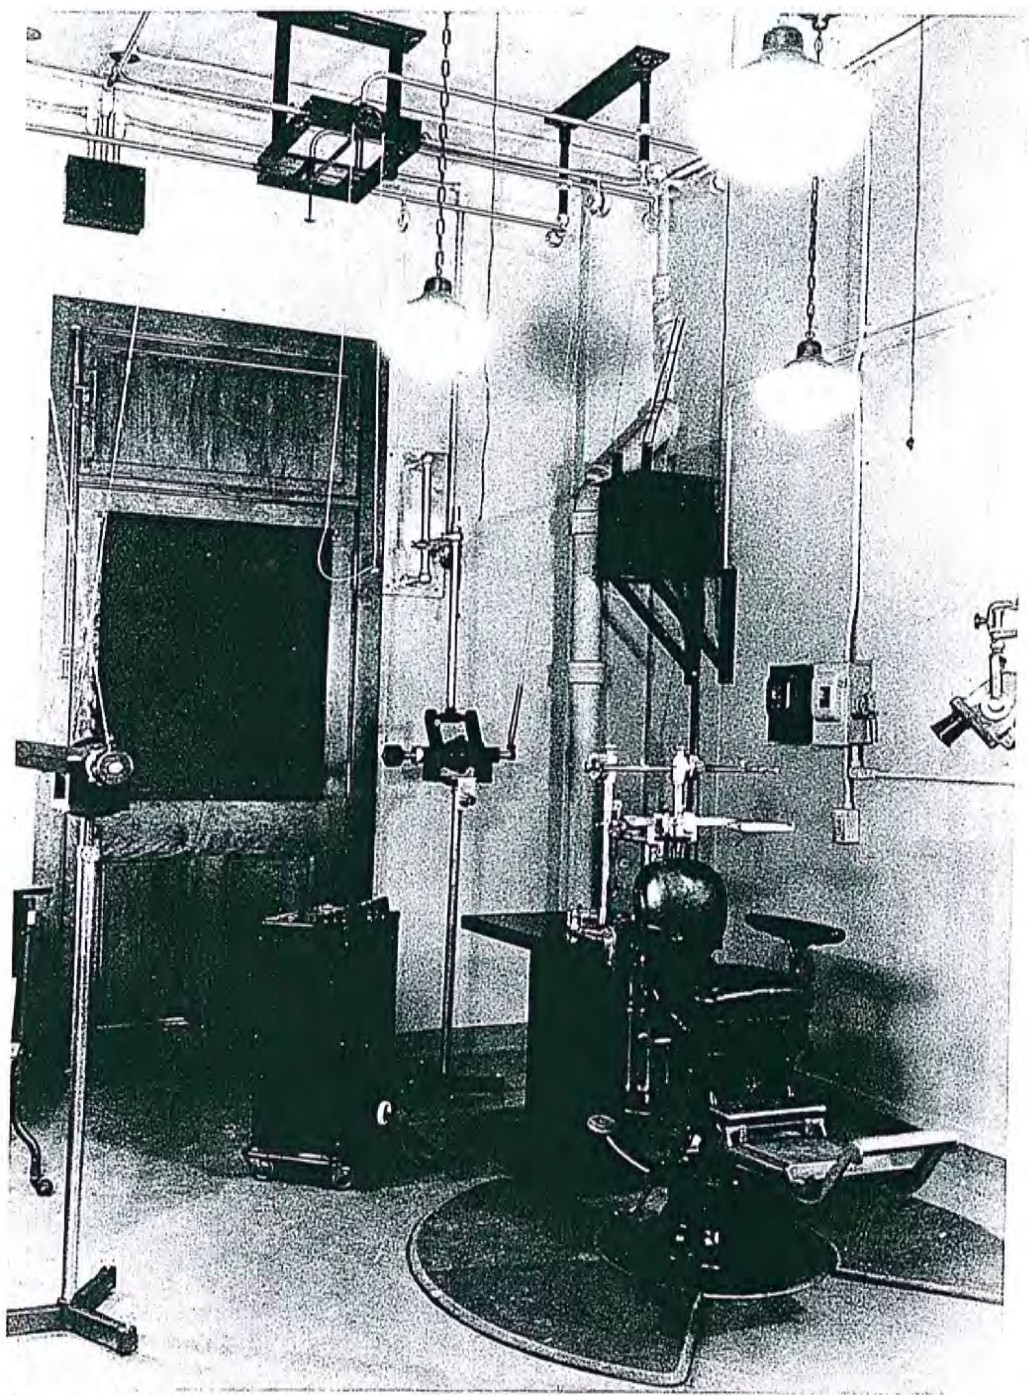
Original Broadbent-Bolton cephalometer, completed in 1929 and designed for taking complementary frontal and lateral cephalometric radiographs. It is the head holder that was used to begin the long-term radiographic study of the growing child.
